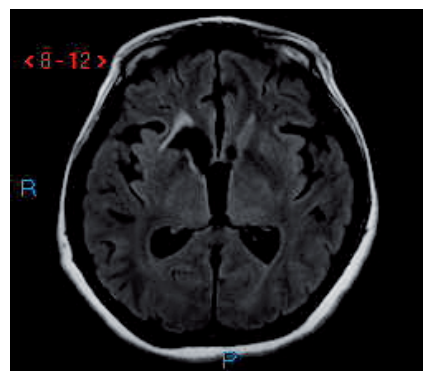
T1 Axial MRI showing severe dilatation of the lateral and third ventricles and a lesion in the region of the right caudate nucleus.
